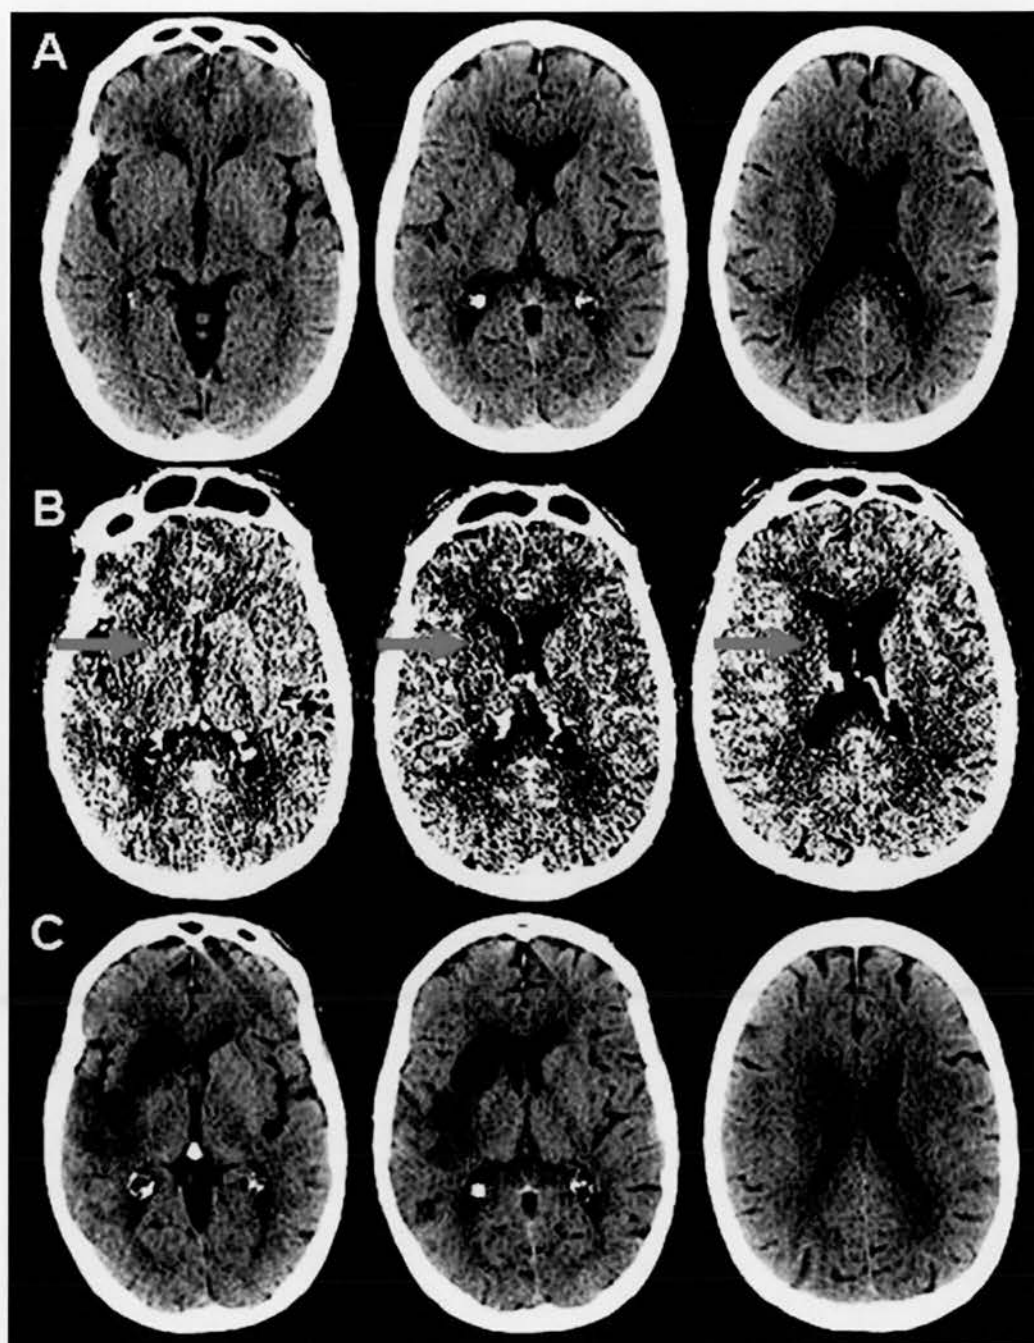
75 year old man with left hemiplegia and hemineglect syndrome caused by a right MCA occlusion. Unenhanced CT scanning was performed 62 minutes after symptom onset; NIHSS was 15 at baseline. A. Possible subtle right lentiform / subinsular ischaemic hypodensity; this scan received an ASPECTS rating of 10 from one of the experts, and 9 from the other. B.
